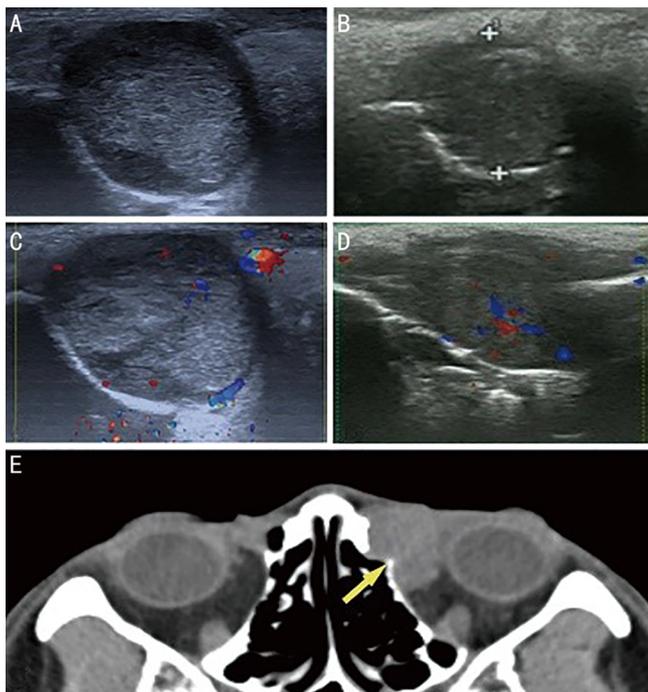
Imaging features of lacrimal sac tumor in CDU and CT-DCG A: A moderate echogenic solid mass filled the entire lacrimal sac, with a well-defined border and inhomogeneous internal echoes; B: A moderate echogenic solid mass filled the entire lacrimal sac, with an unclear border and inhomogeneous internal echoes; C: CDU showed scattered punctate blood flow signals in melanocytic carcinomas; D: CDU showed more abundant blood flow signals in squamous cell carcinomas; E: CT showed soft tissue mass in the lacrimal sac with slight bone erosion (yellow arrow). CDU: Color Doppler ultrasound; CT-DCG: Computed tomography dacryocystography; CT: Computed tomography.
